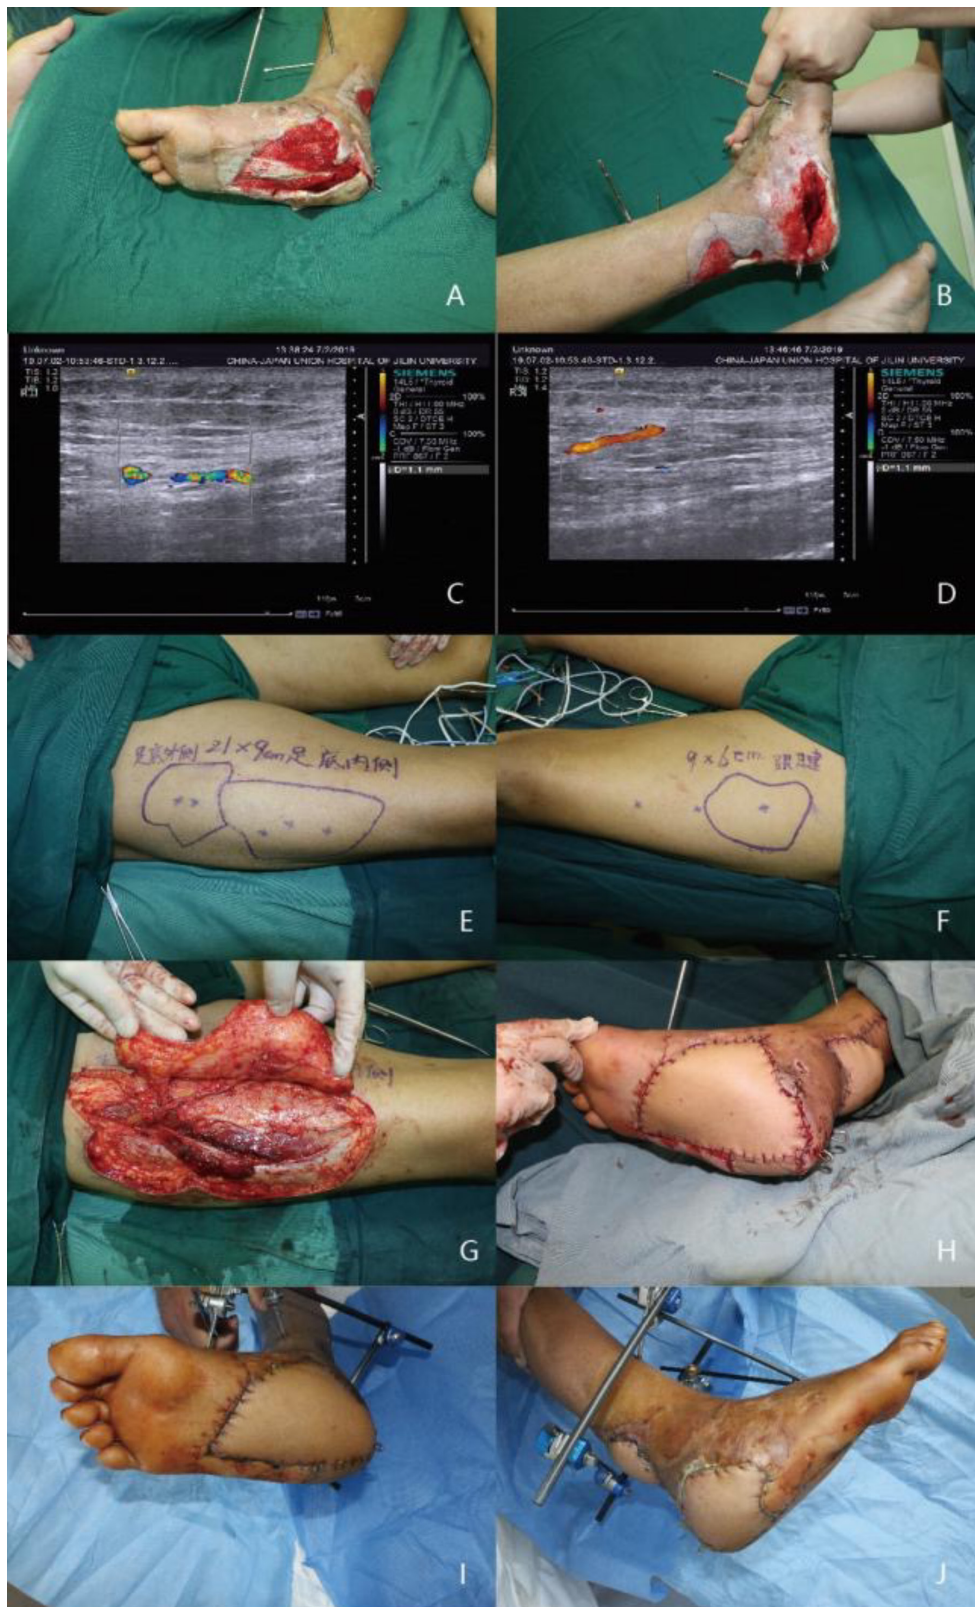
A-B, Large area of skin and soft tissue defect of right foot. C-D, The location of perforator using color doppler ultrasonography preoperatively. E, Design of a free anterolateral thigh perforator flap on right thigh (size: 21.0×9.0 cm²). F, Design of a free anterolateral thigh perforator flap on left thigh (size: 9.0×6.0 cm²). G, Harvest of an anterolateral thigh perforator flap based on the descending branch of the lateral circumflex femoral artery. H, Successful coverage of the defect was achieved. I-J, Postoperative view after two weeks.
